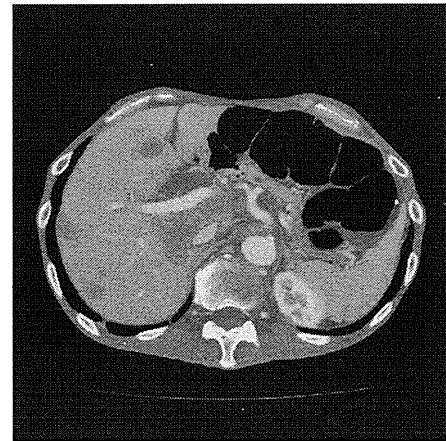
CT scan revealed the presence of multiple hepatic metastases and bone metastasis.
